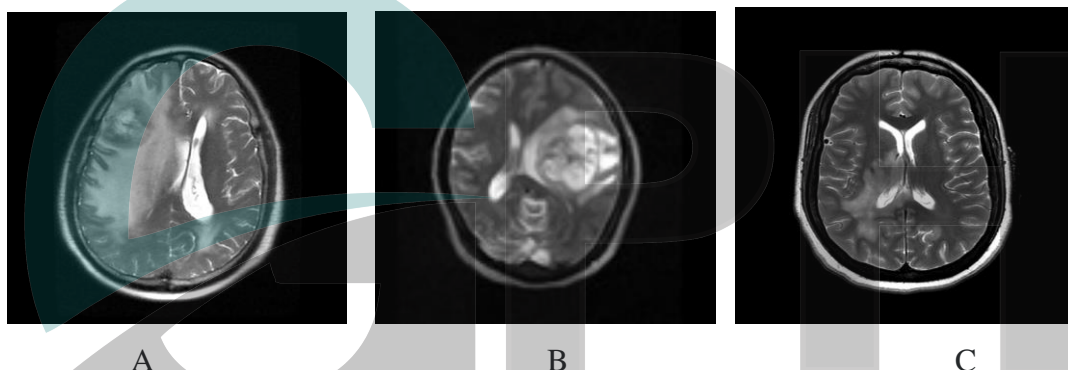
MRI of A. Glioma B. Glioblastoma C. Tumefactive MS
